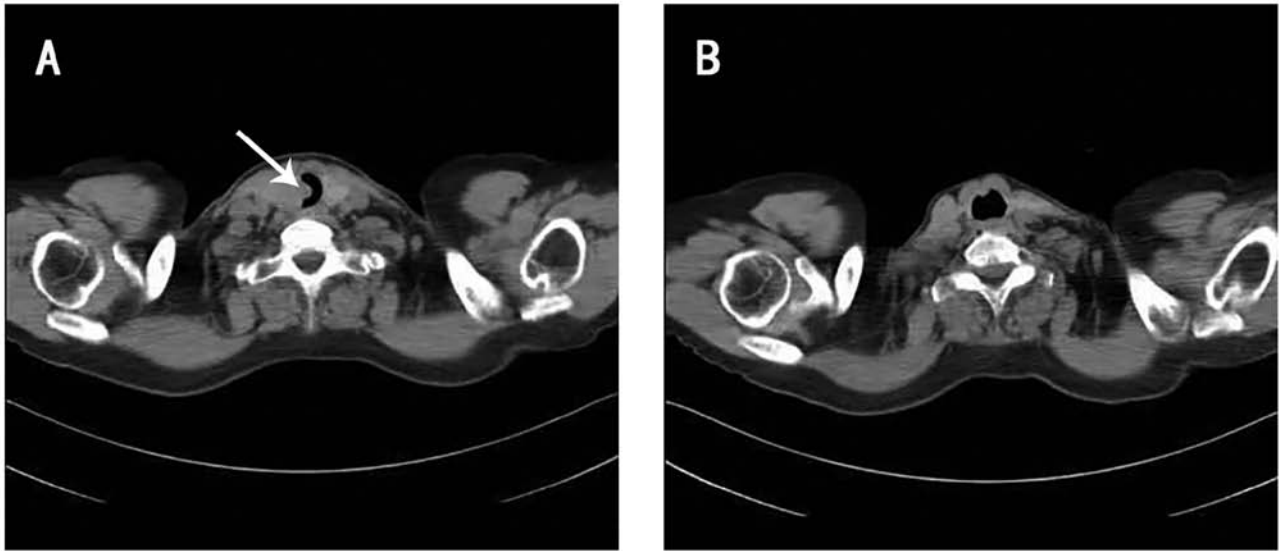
Neck computed tomography of the tumor and trachea. (A) Tumor invasion of the trachea 2 weeks before the surgery (white arrow). (B) The trachea was unobstructed and no recurrence was found 6 months after the surgery.
